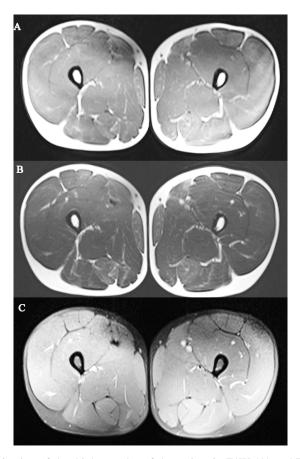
The MRI examination of the thigh muscles of the patient in T1W (A) and T2W (B) images, showing slight changes in the sartorius, gracilis and semitendinosus, and no changes in the STIR images (C).
